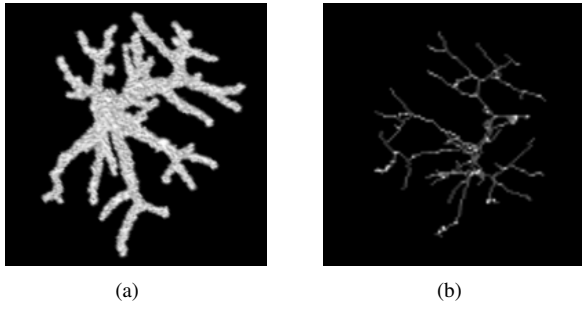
Hepatic vessel reconstruction: (a) 3D model from CT images. (b) Unit-width skeleton of vessel tree
